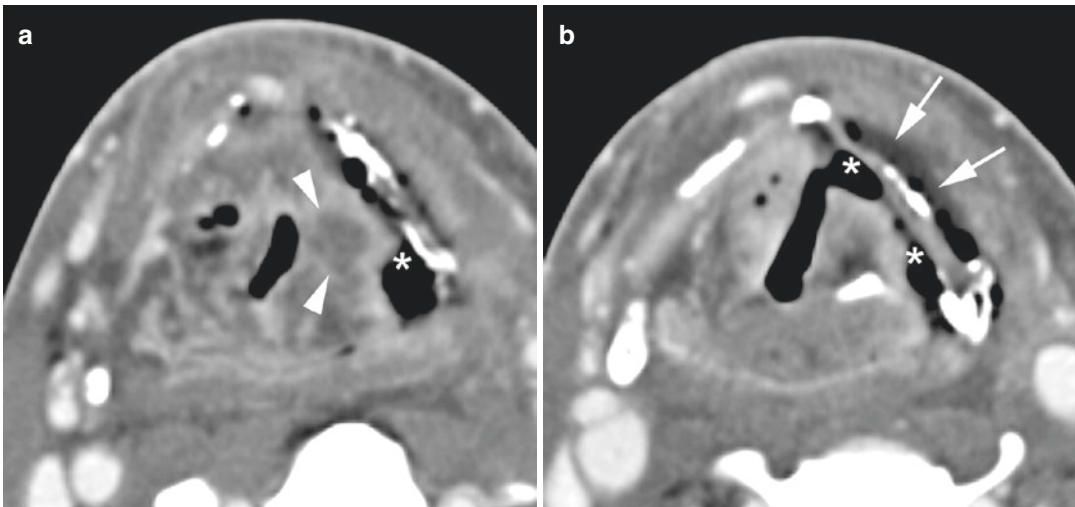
Axial contrast-enhanced CT images. Patient treated 5 months earlier by irradiation for T3 supraglottic cancer, suffering from progressive dysphagia. Laryngoscopy showed a fixed left vocal cord, suspect for tumor recurrence. (a) On a background of expected changes after radiation therapy, a centrally hypodense nodular area of soft tissue thickening is seen in the left aryepiglottic fold (arrowheads). Furthermore, a large soft tissue defect (asterisk), connecting the left piriform sinus with the denuded thyroid cartilage lamina, is seen. The
